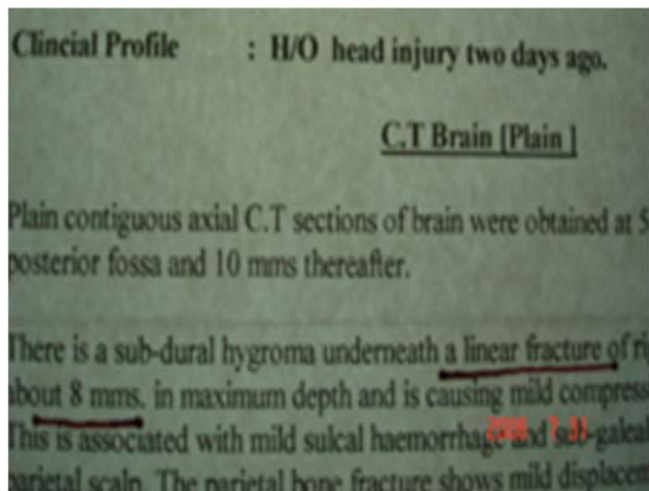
Printed report is of the CT brain-scan done when baby was 4months of age -reporting the linear fracture.
